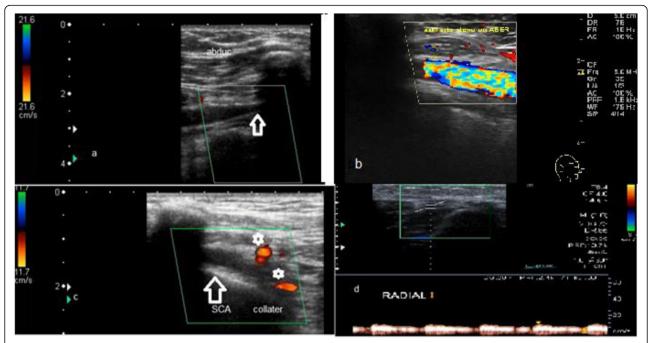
a Color image of the axillary-subclavian artery junction showing tapered significant narrowing of the artery on arm abduction with a peaking of the artery toward the costo-clavicular space (white open arrow). Note the flow cessation in the examined artery. b Color image for the same arterial segment in another patient showing marked color aliasing due to high-velocity jet of the arterial stenosis at the outlet of the costo-clavicular space. c Color Doppler image showing complete cessation of the arterial flow on arm abduction (open white arrow) and the presence of regional arterial collaterals (white asterisks) circumventing the obstruction. d Spectral Doppler image showing tardus parvus waveform that was interrogated in the distal radial artery on arm abduction. This was correlated clinically with an obliterated or a weak radial pulse
